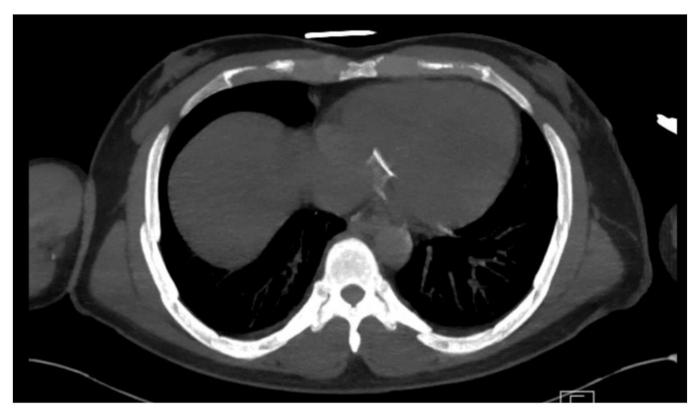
Post-neck exploration CT imaging of needle fragment now located in the heart after embolization.
